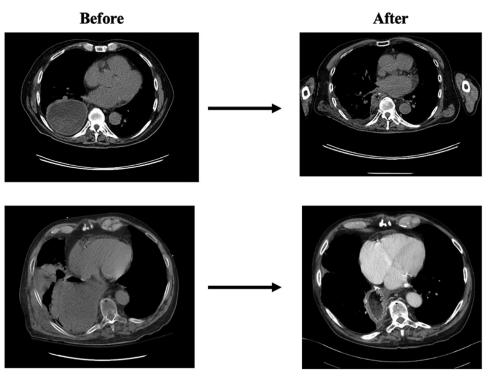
CT scans of patients before and after conduit revision. CT, Computed tomography.
